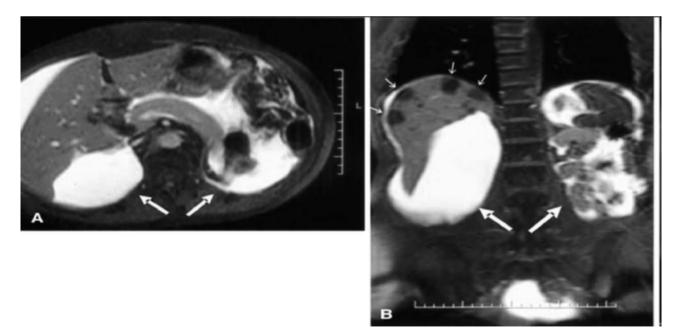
Retroperitoneal fluid leak. (a) axial and (b) coronal T1-weighted images demonstrate retroperitoneal fluid leak (large arrows) in a patient who had bilateral nephrectomy secondary to polycystic kidney disease. Note multiple liver cysts (small arrows). With permission from Springer Science and Business Media [361]
